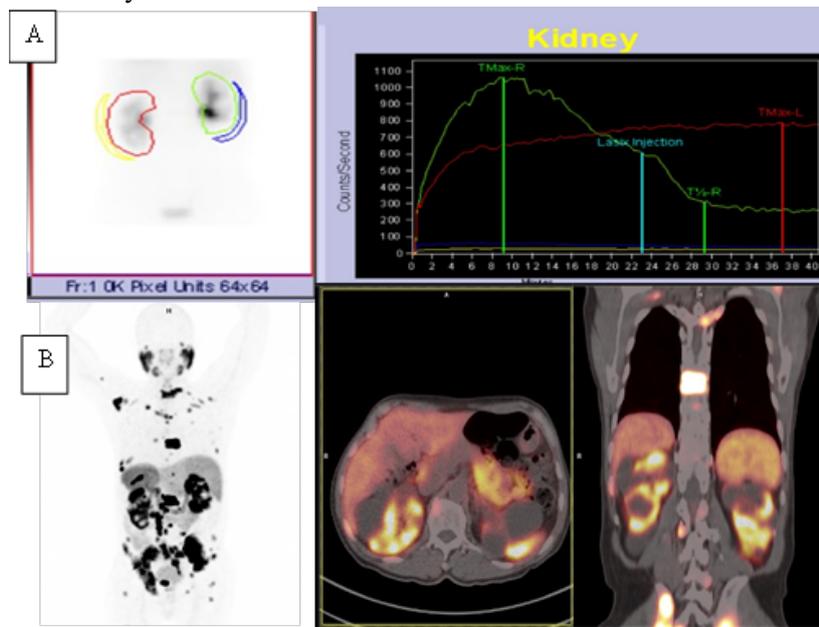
^{99m}Tc -MAG3 renogram images (A) showing left kidney obstruction. ^{68}Ga -PSMA PET/CT images (B) showing multiple kidney cysts bilaterally with decreased tracer uptake and a stasis of radiotracer in a dilated collecting system.
